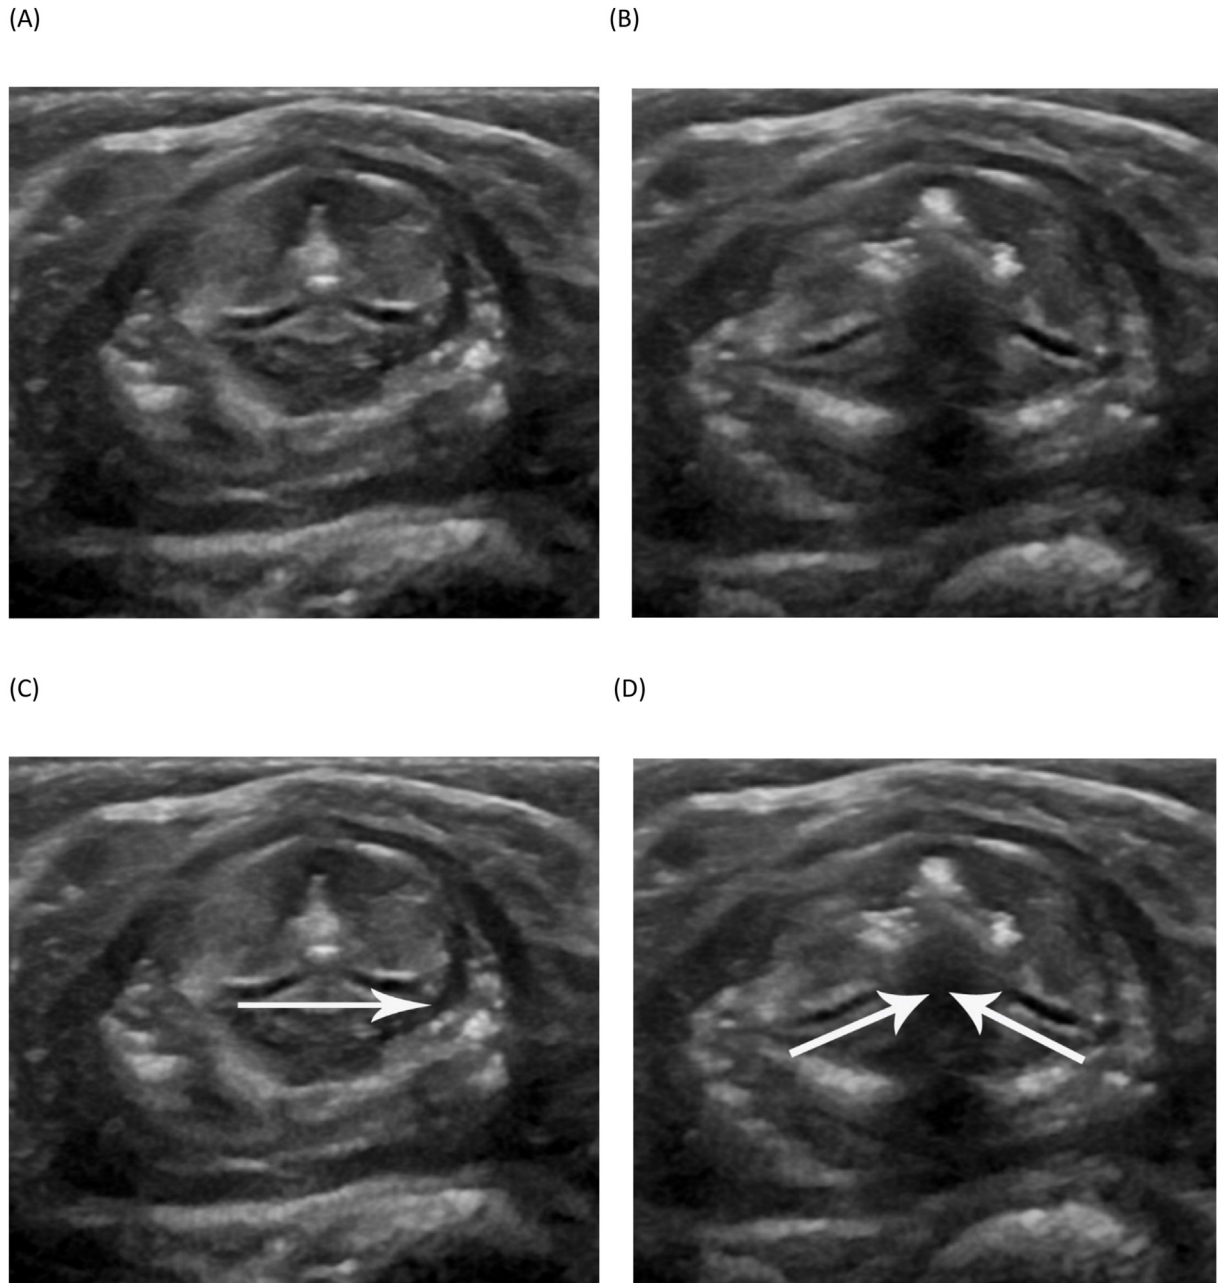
Two still frames taken from a transverse laryngeal ultrasound cine clip in a 7-month-old boy with normal vocal fold motion. The paired arytenoid cartilage assumes a near horizontal plane at rest (A and C) but pulls to a symmetrical sloping plane with motion (B and D).
